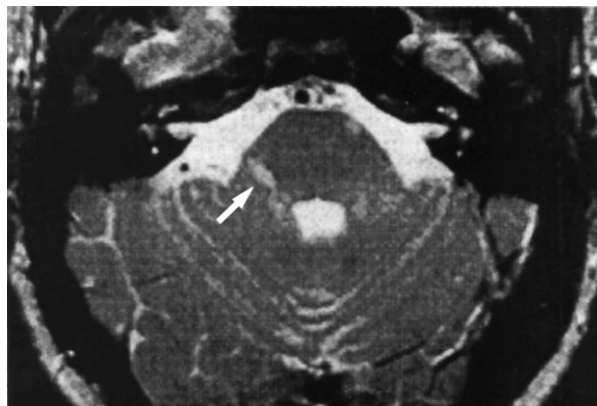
Lesion in the central portion of the trigeminal nerve as shown by magnetic resonance imaging in a patient with trigeminal neuralgia from multiple sclerosis. (Reproduced from Gass et al., 1997, with the permission of the American Academy of Neurology and Lippincott, Williams and Wilkins.)
